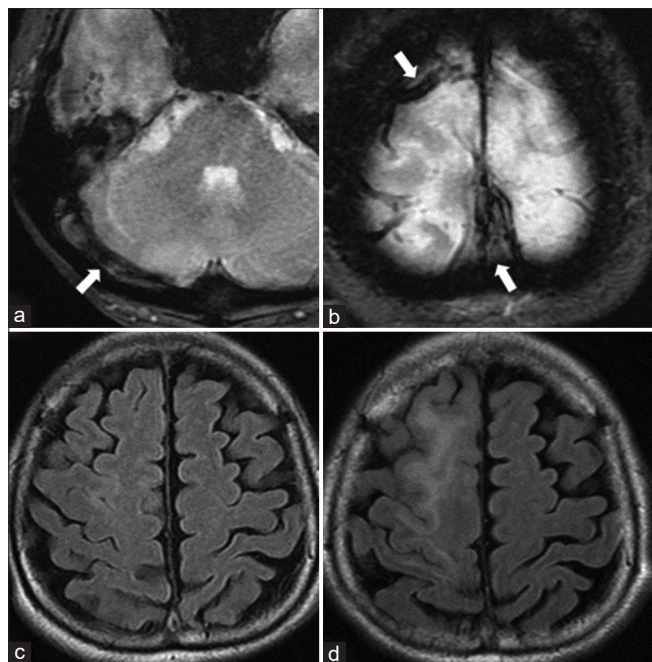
(a and b) Magnetic resonance images showing extensive thrombus (arrows) in sigmoid sinus, superior sagittal sinus, and right cortical vein. (c) Fluid-attenuated inversion recovery (FLAIR) image on admission. (d) FLAIR image on neurological deterioration.
